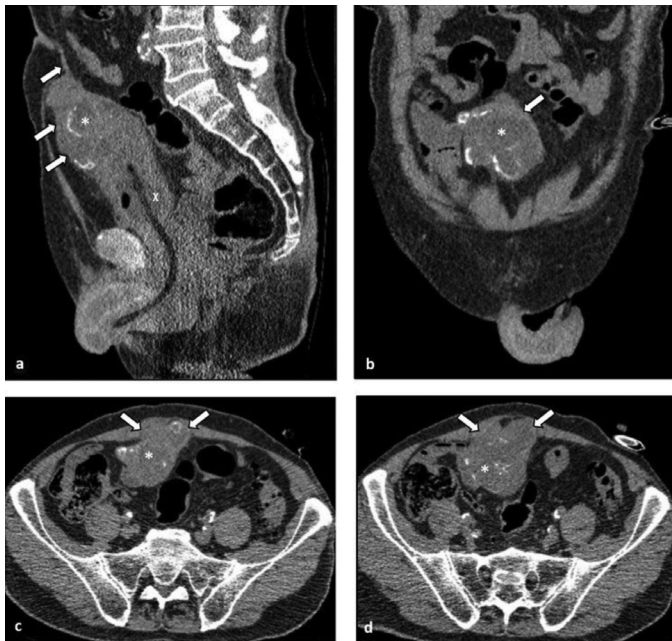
On sagittal (a), coronal (b), and axial (c, d) non-contrast CT images, a large solid mass (arrows) is observed extending from the anterosuperior segment of the bladder toward the anterior abdominal wall and umbilicus, containing curvilinear calcifications and hypodense areas (*) most likely corresponding to mucinous content, with indistinct borders from the bladder walls.
